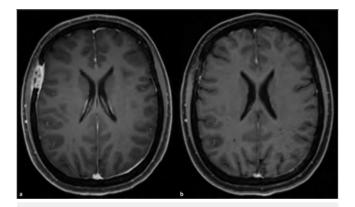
MRI of the same patient. The patient has a primarily osseous manifestation of Langerhans cell histiocytosis. According to the classification, it is therefore referred to as a single-system disease, as only a primary osseous manifestation on the skull could be detected in the staging. Isolated foci of inflammation could thus also be delineated on the cranial calvaria, including the extension of the inflammatory process per continuitatem to the adjacent pachymeninx.
